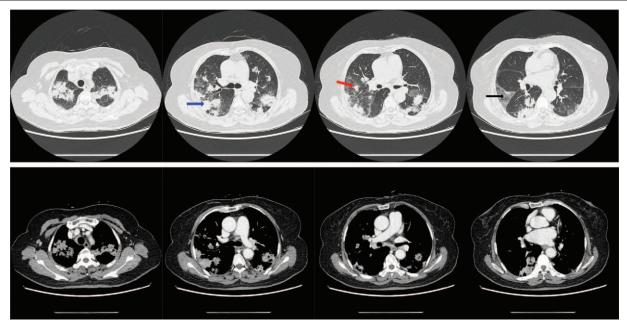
Computed tomography (CT) images at admission. At admission, CT scan showed multifocal areas of consolidations (blue arrow), nodules (red arrow), and ground glass opacities (black arrow) in both lungs, with cervical and axillary lymph node swelling and a little pleural effusion.
